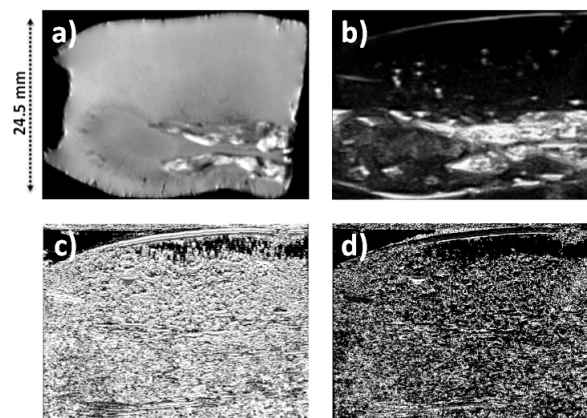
Similarities between a) MRI Slice b) B-Node Ultrasound acquisition, c) damping ratio model image and d) Undamped natural frequency model image.
